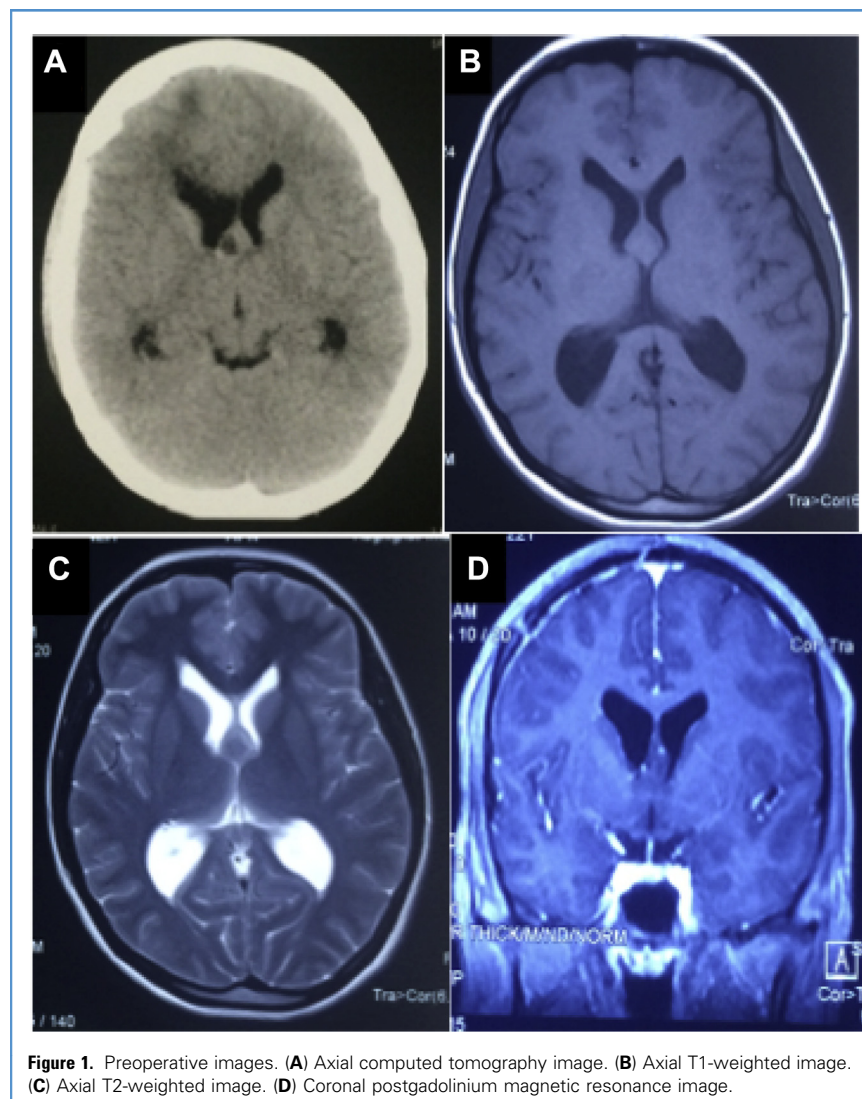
Preoperative images. (A) Axial computed tomography image. (B) Axial T1-weighted image. (C) Axial T2-weighted image. (D) Coronal postgadolinium magnetic resonance image.
